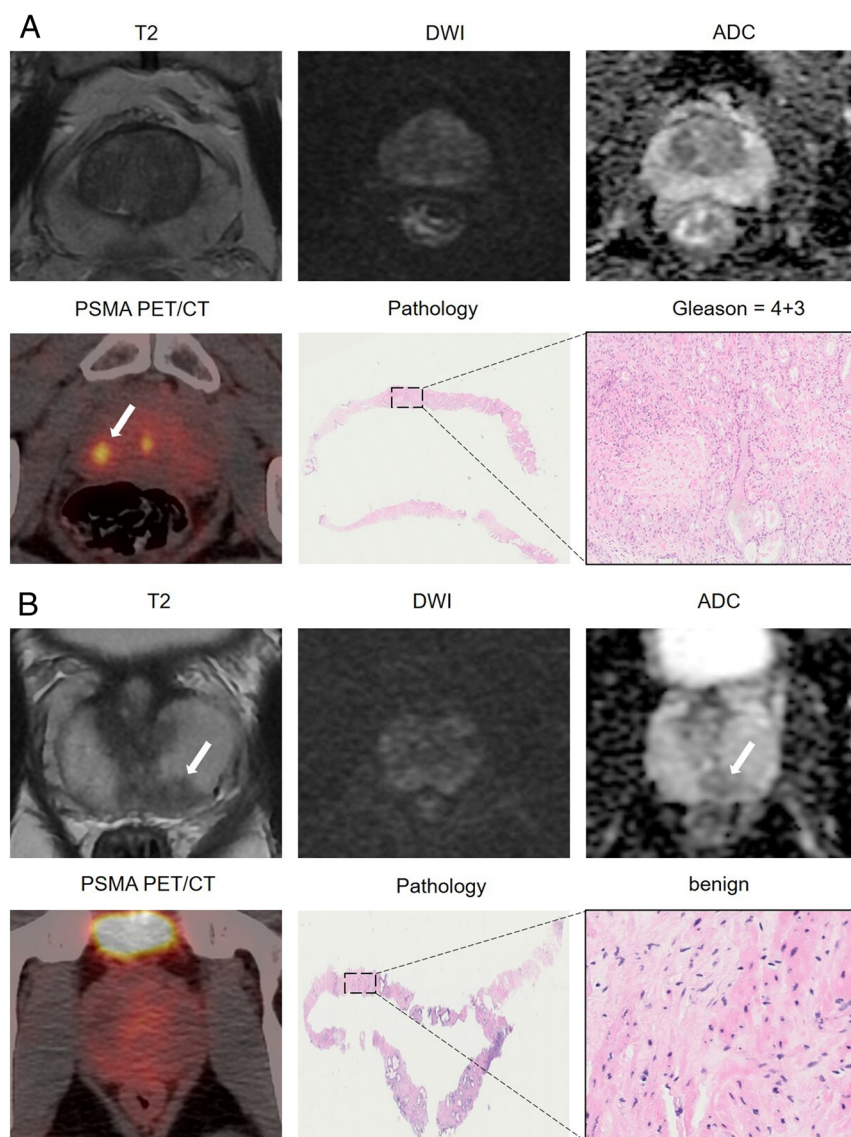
A, A 73-year-old man was defined as PI-RADS 1 on MRI. The corresponding ^{68}Ga -PSMA PET/CT showed a focal PSMA activity lesion (arrow) involving the right peripheral zone (SUV_{max} , 6.9), defined as PRIMARY score 4 and confirmed to be ISUP 3 on biopsy pathology. This case can be correctly diagnosed as positive by the combination of PRIMARY score + MRI to avoid the false-negative of MRI. B, A 56-year-old man was defined as PI-RADS 3 on MRI. The corresponding ^{68}Ga -PSMA PET/CT showed diffuse PSMA uptake without any focal activity (SUV_{max} , 3.6), defined as PRIMARY score 2 and confirmed to be benign on biopsy pathology. This case can be correctly diagnosed as negative by the combination of PRIMARY score + MRI to avoid unnecessary biopsy. ADC indicates apparent diffusion coefficient.
